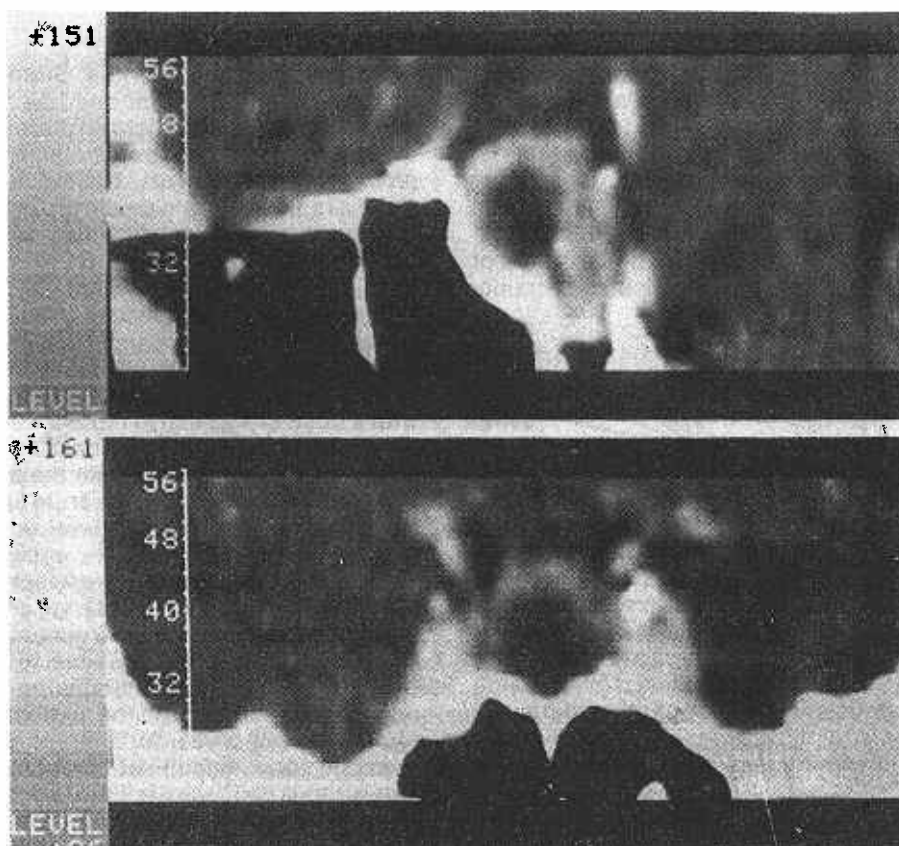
Sagittal (top) and coronal (bottom) reconstructions of a CT scan in a young woman who presented with amenorrhoea and a high prolactin level. There is a large macroprolactinoma with suprasellar extension.
